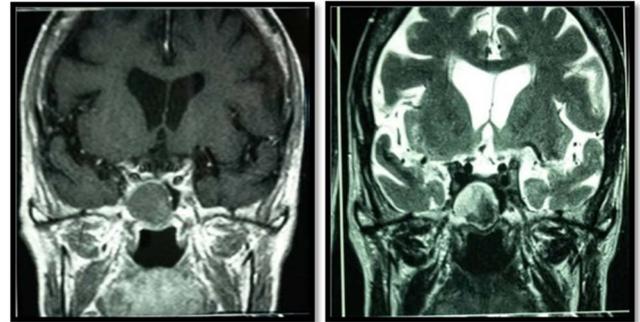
Coronal MRI imaging demonstrating a sphenoidal mucocoele (isointense T1 weighted images and hyperintense T2 weighted images).
